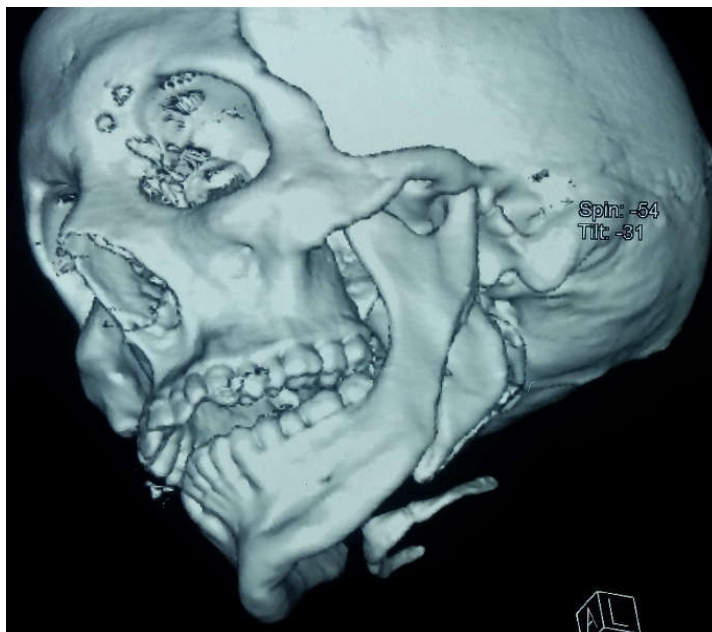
Preoperative CT scan of patient showing unusual fracture pattern
